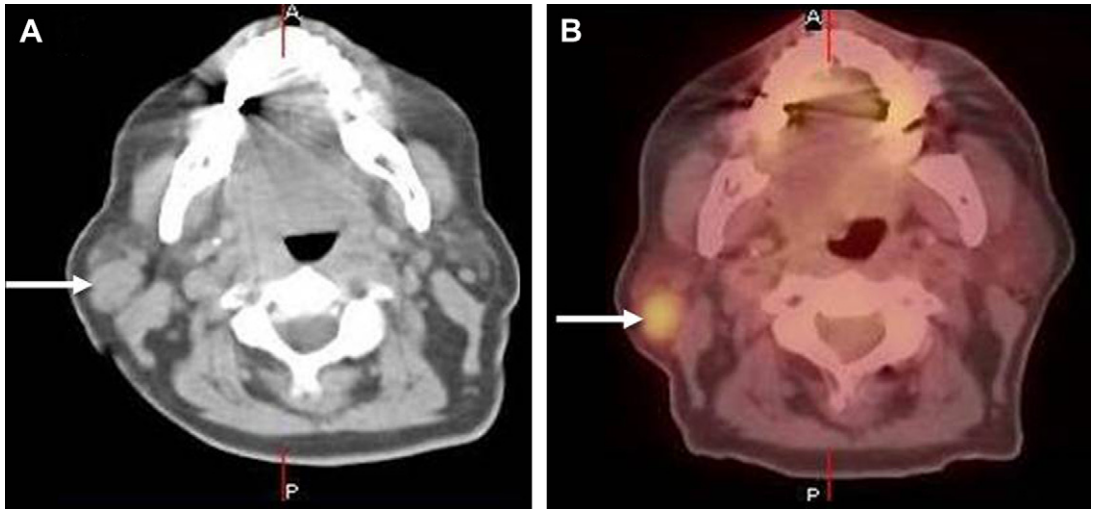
Elevated FDG uptake in a benign tumor. (A) Axial noncontrast CT shows a mass (*arrow*) in the right parotid tail. (B) Fused PET-CT image shows hypermetabolism in the mass (*arrow*). On biopsy the mass represented a Warthin tumor.
